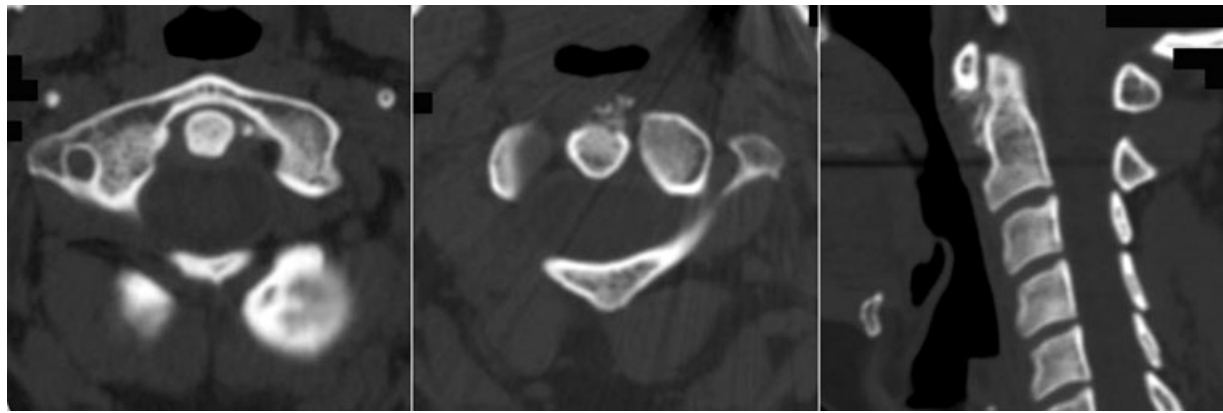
Axial CT slices (left and middle images) show calcified deposits anteriorly and to the left of the dens, with erosion of the anterior cortex of the odontoid peg. Sagittal reformatted image (right) confirms the erosion and the relation of the deposits with the anterior arch of C1.
